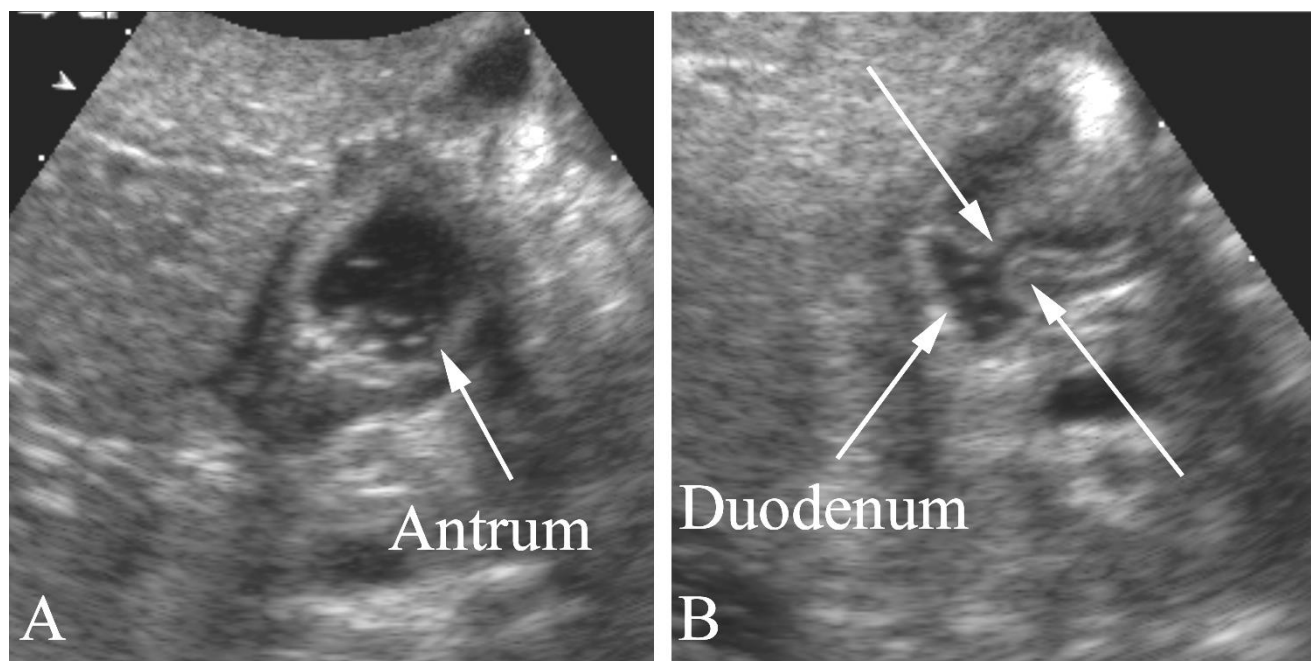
Normal pylorus in a 3 month old female infant with persistent projectile vomiting. A. Ultrasound examination through the mid-abdomen following oral administration of water/electrolyte solution shows the stomach antrum (arrow). B. Ultrasound examination obtained by constant observation of the antrum of the stomach following oral water demonstrates fluid in the distal antrum, pylorus, and duodenum. The arrows show the margins of the normal pylorus.
